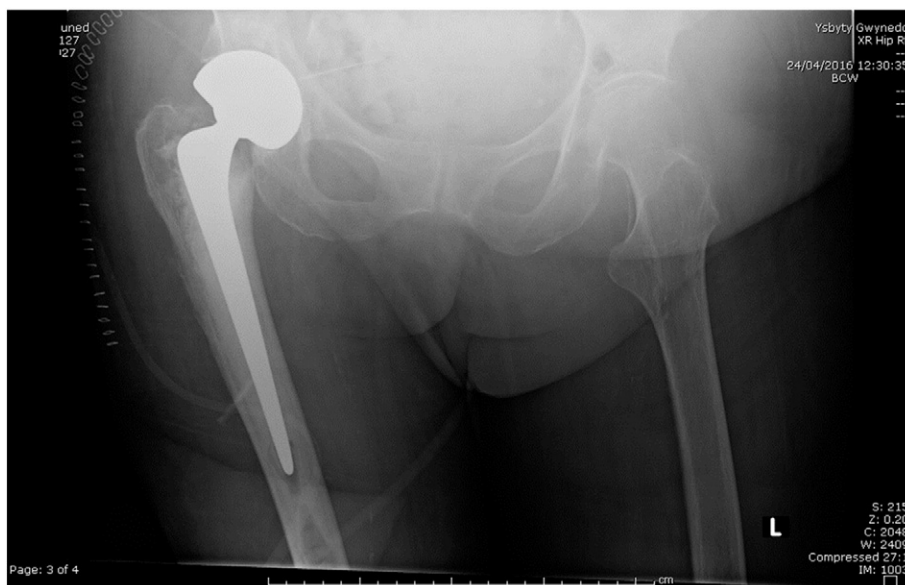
postoperative X-ray following THR.
